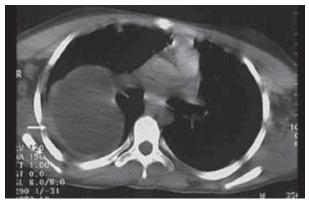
Computed tomography revealed a thin walled, hypodense round lesion (8x4 cm) (arrow) in the superior segment of right lower lobe.
